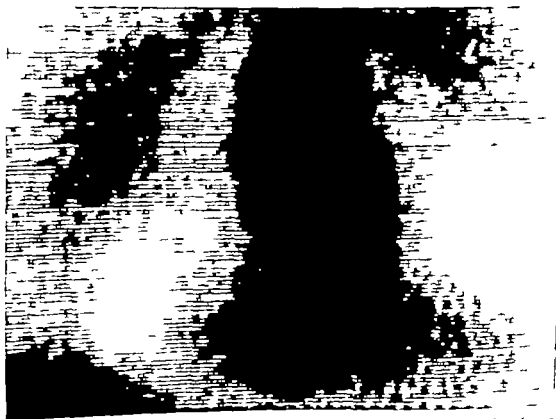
Cardiac blood pool scan (Case 2) showing a small intracardiac blood pool compared to the roentgenologic heart size. There is wide separation between the heart (dark central area) and the lungs on both sides, as well as between the heart and the liver. The light area surrounding the cardiac blood pool represents pericardial tumor.
